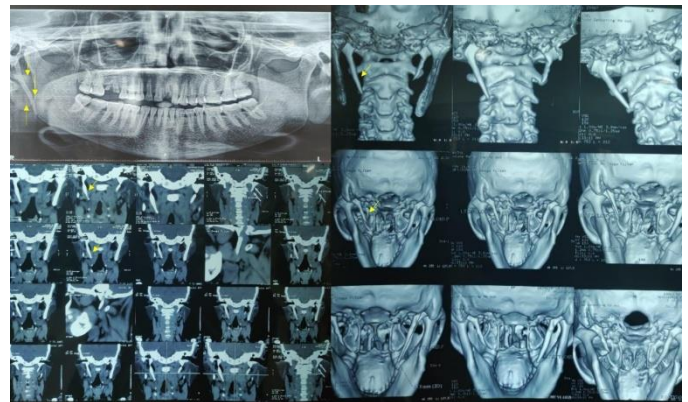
OPG shows elongated styloid process on the left side. CT Coronal section shows elongated styloid process in the left side.
